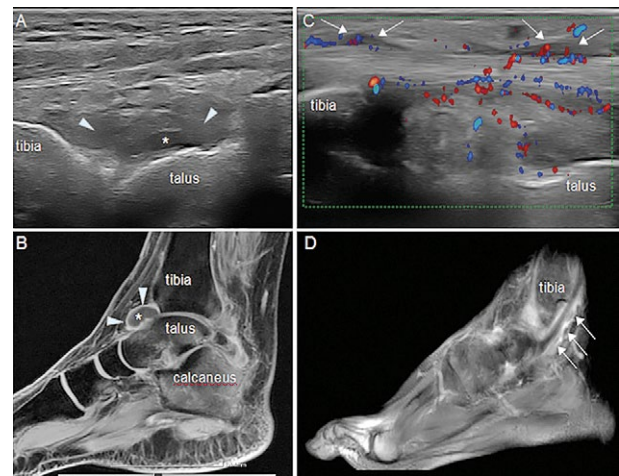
Longitudinal US image (A) and sagittal T1 weighted post-gadolinium 3D LAVA MRI (B) at anterior recess of tibiotalar joint reveal synovial hypertrophy (arrow heads) and joint effusion (*) in an RA patient. Longitudinal US image (C) and sagittal T1 weighted fat saturated post-gadolinium MRI image (D) of tibialis posterior tendon reveal tenosynovitis (arrows) with synovial proliferation and peri- and intra-tendineous PD signals in an RA patient.
